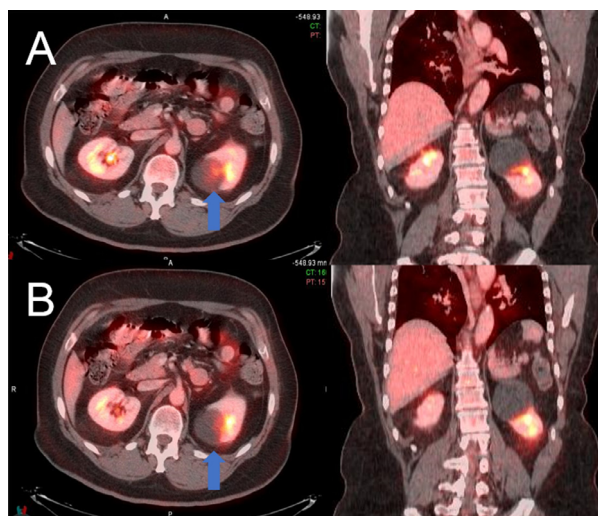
PET/ceCT of a 67-year-old woman with sequential CT and PET acquired during normal breathing. A, original fused images, axial and coronal, show a 3 × 5 cm benign left renal cyst with PET/CT misregistration due to respiratory motion (arrow). B shows manually adjusted PET/CT registration, axial and coronal; however, minimal misregistration remains due to the inherent differences in the respiratory motion between CT and PET (arrow). In clinical practice, a manual co-registration is feasible but will slow down the image review and interpretation process. Still, a manual co-registration is subjective and may not solve the misregistration well.
